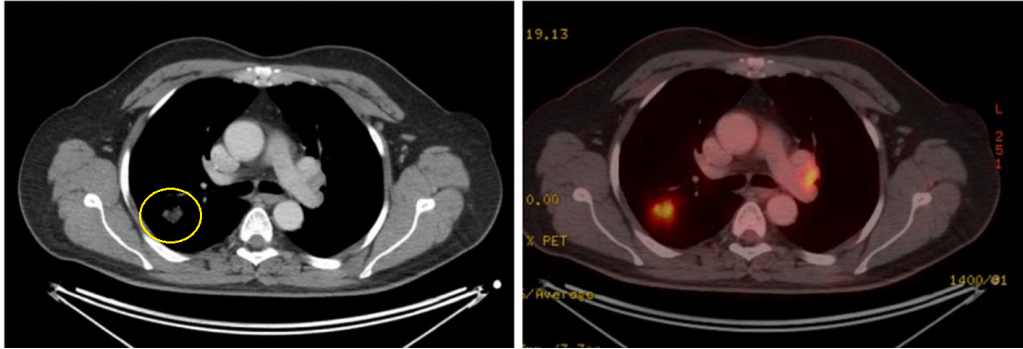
A regular CT (left) and a PET/CT (right) of a patient with NSCLC. While the primary tumor is visible on the CT, the FDG-PET also detected contralateral affected lymph nodes.
